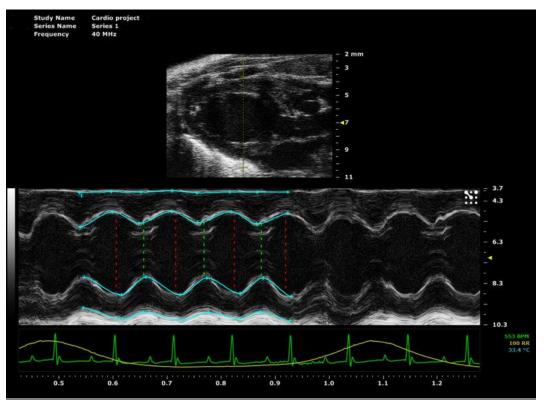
M-Mode image of parasternal long axis view displaying motion of the anterior and posterior walls.
